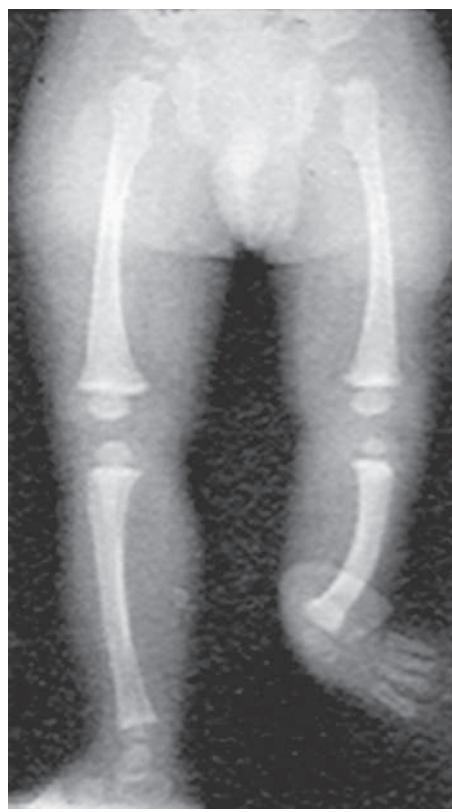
Anteroposterior radiograph of fibular hemimelia with leg-length discrepancy.
